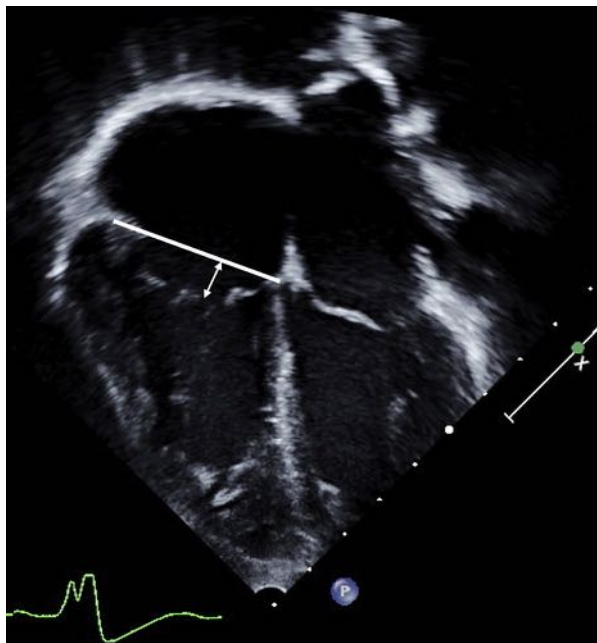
Apical four-chamber view (systolic frame) showing measurement of TV tethering height.
